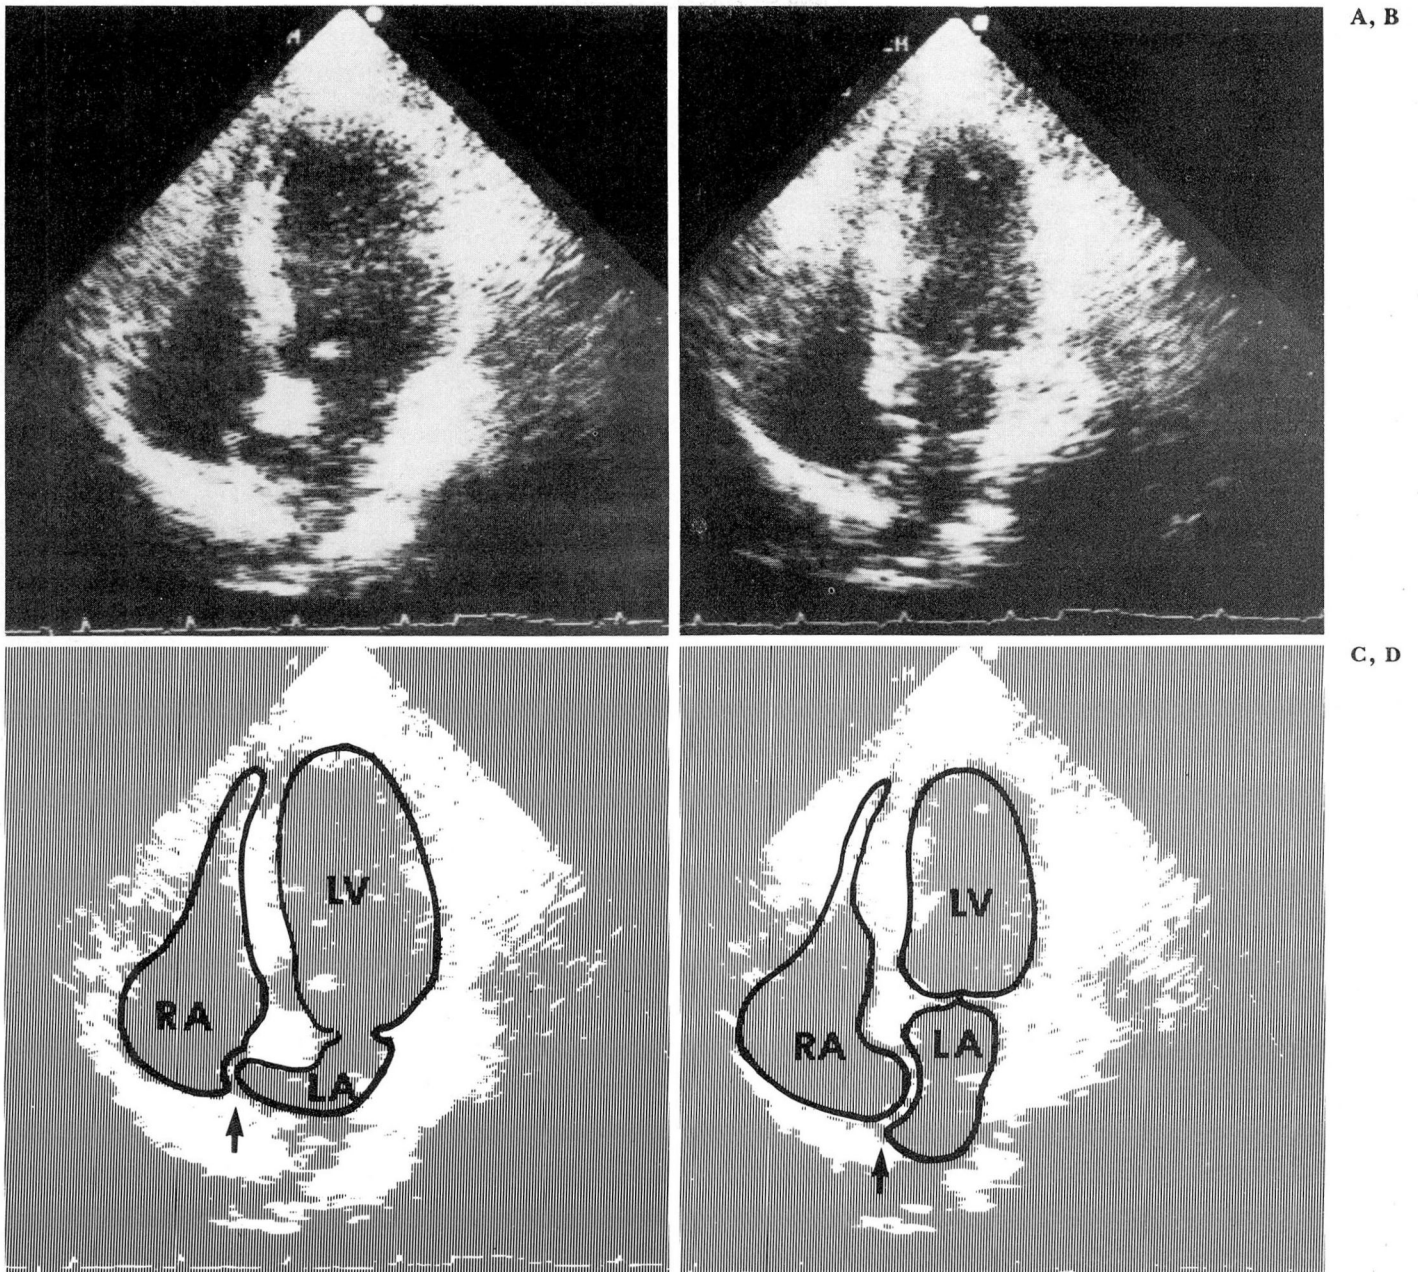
Two-dimensional echocardiogram in an apical four-chamber view.
